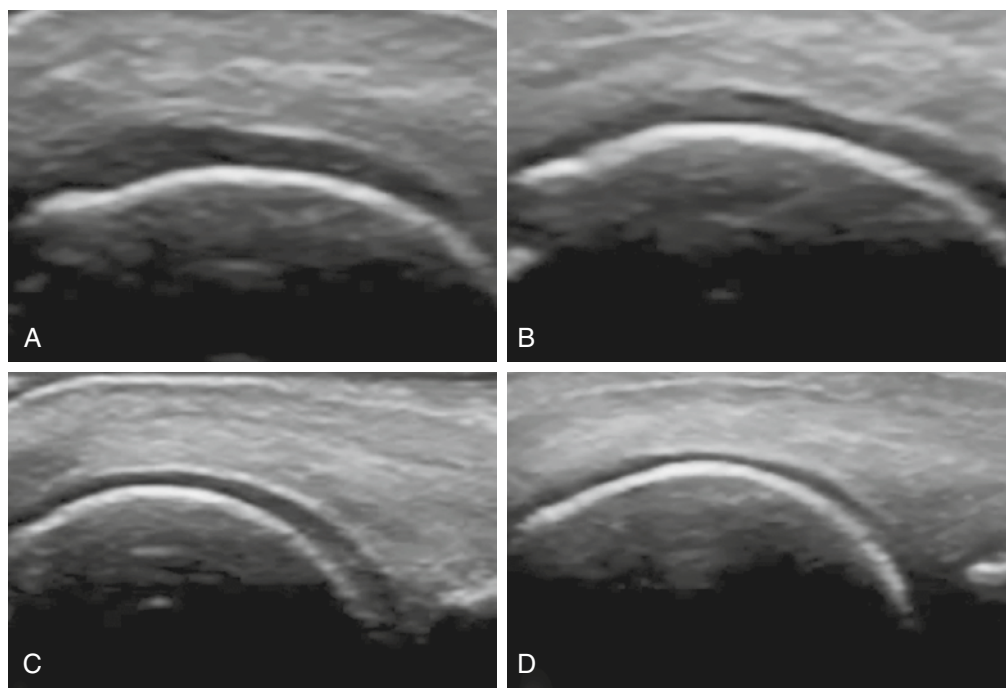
Anterior longitudinal scans are used to evaluate the hyaline cartilage of the second metacarpal head in a patient with osteoarthritis. A-D, The 15-MHz ultrasound images demonstrate progressive alterations characterized by loss of sharpness and blurring of the superficial and deep edges, changes in the echotexture with a hypoechoic appearance, and progressive cartilage thinning.
